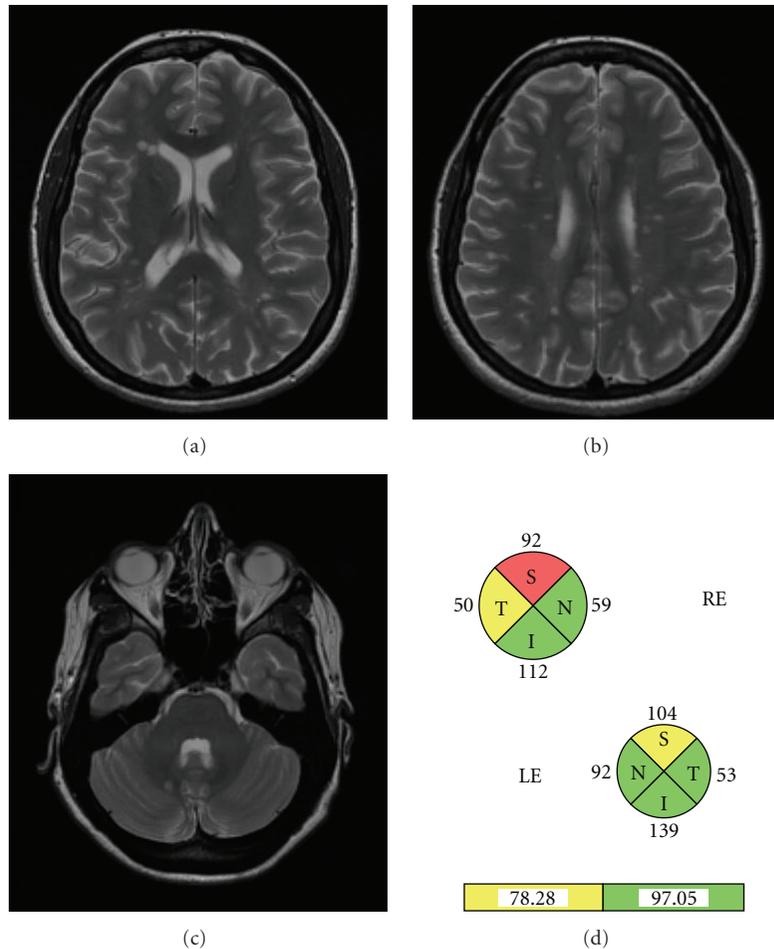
Patient who suffered a motor clinical isolated syndrome and fulfilled Barkhof's magnetic resonance imaging criteria. Optical coherence tomography shows a decreased retinal nerve fiber layer in both eyes (more intense in the right eye) even without a history of optic neuritis.
